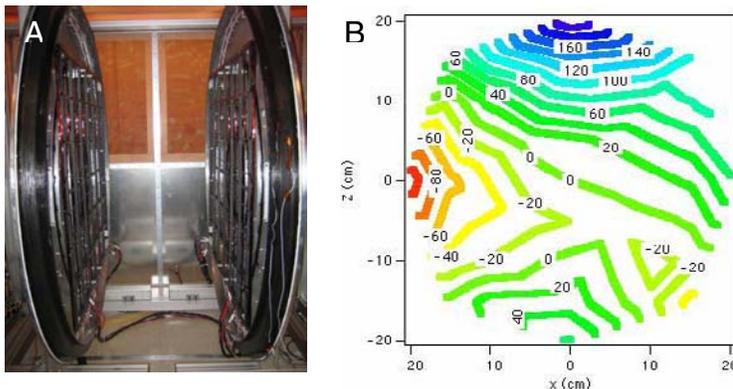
Low-Field MRI system and initial field map.
